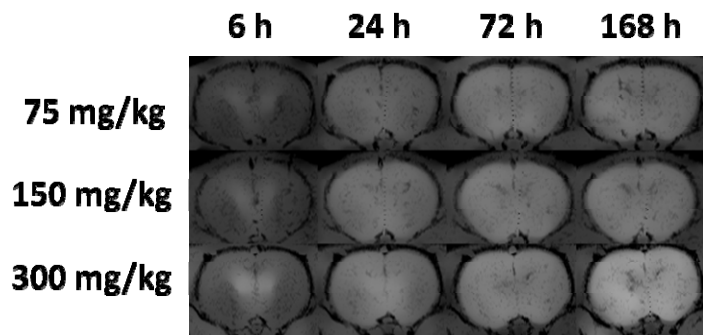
Dose dependence and time course of MEMRI contrast. T_1 -weighted axial MR image sets are shown as a function of varying doses of $MnCl_2$ and as a function of time after subcutaneous injection of $MnCl_2$.
